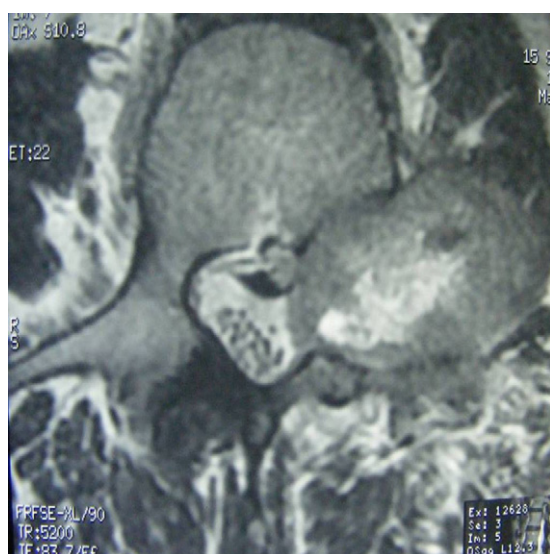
T2-weighted axial MRI shows areas of hemorrhage within the tumor.
